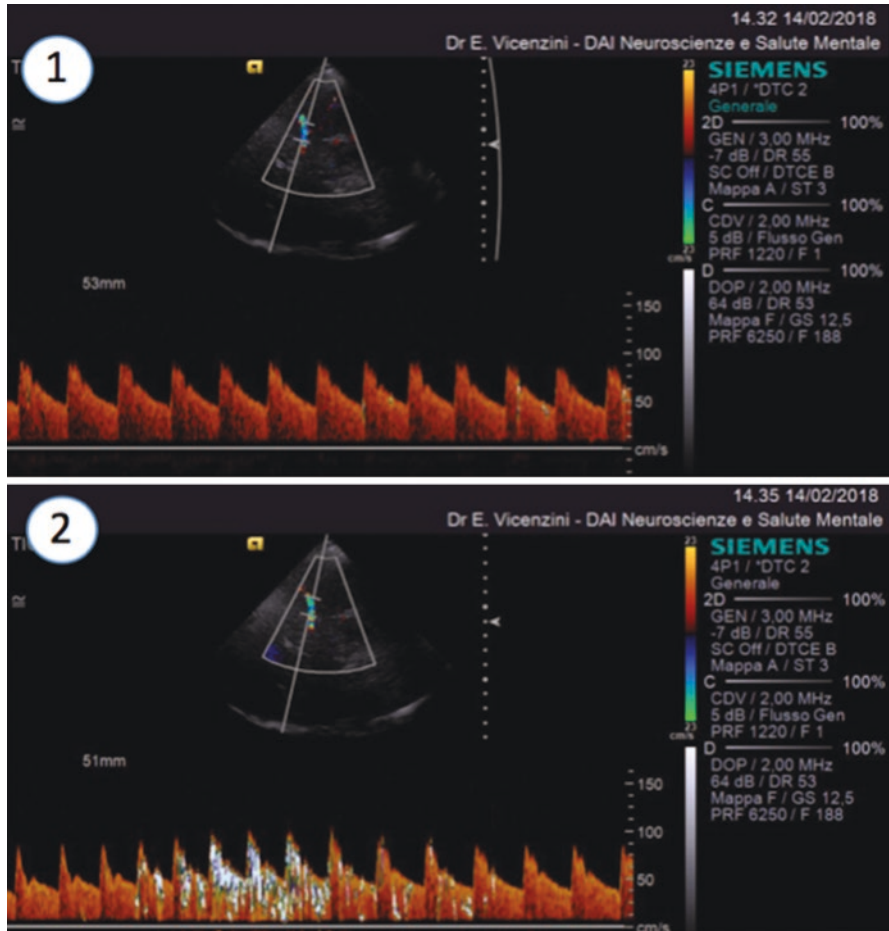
Example of TCCS with saline to RLS identification, detected only after Valsalva maneuver: (1) basal; (2) Valsalva maneuver. MES are identical to those observed with TCD on the Doppler spectrum, but with short monitoring time and lack of power M-Mode
